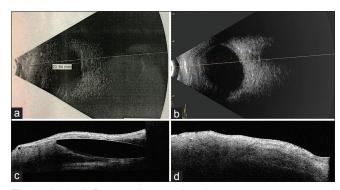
(a-d) B-scan ultrasound and anterior segment optical coherence tomography images. Preoperative B-scan image depicting vitreous opacity suggestive of vitreous hemorrhage with intact retina. Postoperative B-scan shows a clear and a normal posterior segment. Preoperative anterior segment optical coherence tomography depicting the subconjunctival extrusion of an intraocular lens. Postoperative anterior segment optical coherence tomography depicting a normal subconjunctival space with apposed wound
